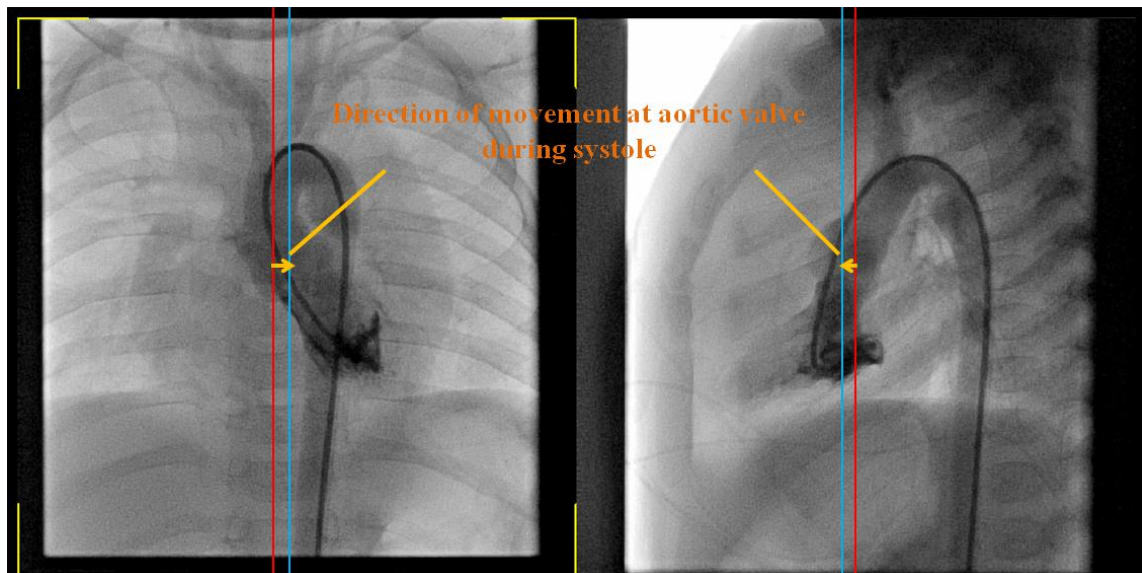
CT image at minimum volume of ventricle (left: front view, right; side view)
